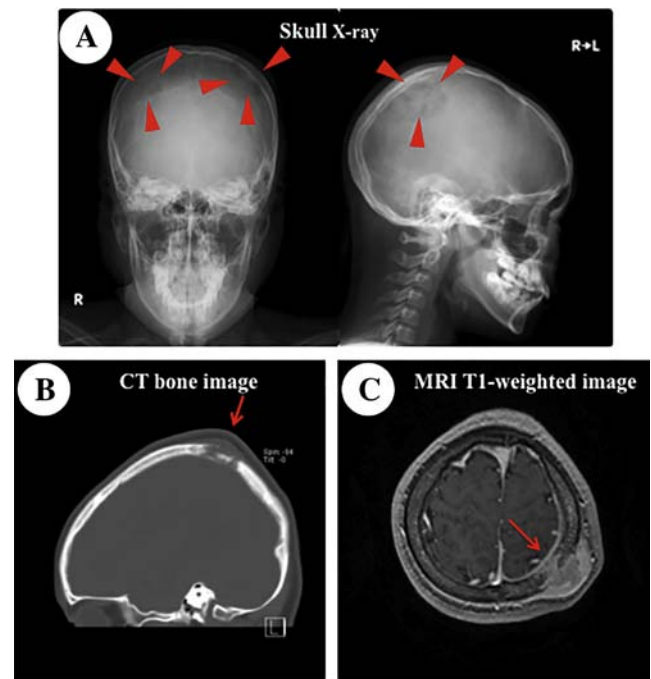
Radiological examinations of the skull-associated mass lesion. A, Skull radiographs showed round foamy shadows indicated by arrowheads. B and C, A sagittal bone image by CT and a horizontal image by T1-weighted magnetic resonance imaging are shown. Arrows indicate the growing tumor mass accompanied by destruction of the cranial bone.
